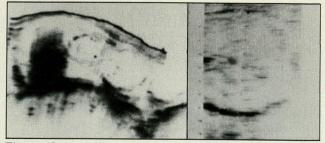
(Case 1). Ultrasonogram at 30 weeks' gestation demonstrates poor delineation of fetal head and minimal fetal ascites.
